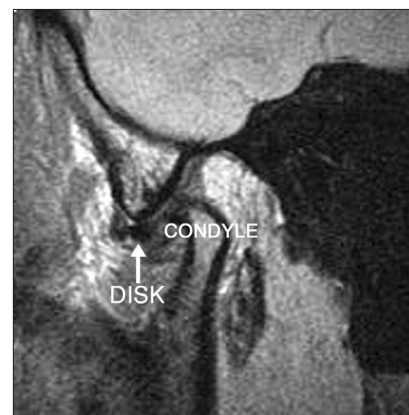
Magnetic resonance imaging of the mouth in the open position showing the disc remaining forward and not returning to a position between the 2 articulating surfaces.
